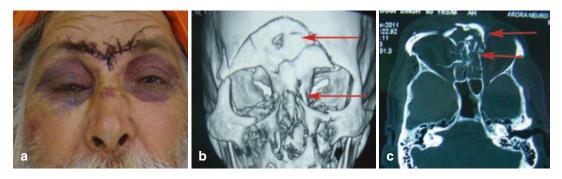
Naso-orbital fracture – clinical and radiologic pictures. (a) Showing bilateral circum-orbital ecchymosis. (b) 3D-CT showing the nasal bone fracture. (c) Axial
